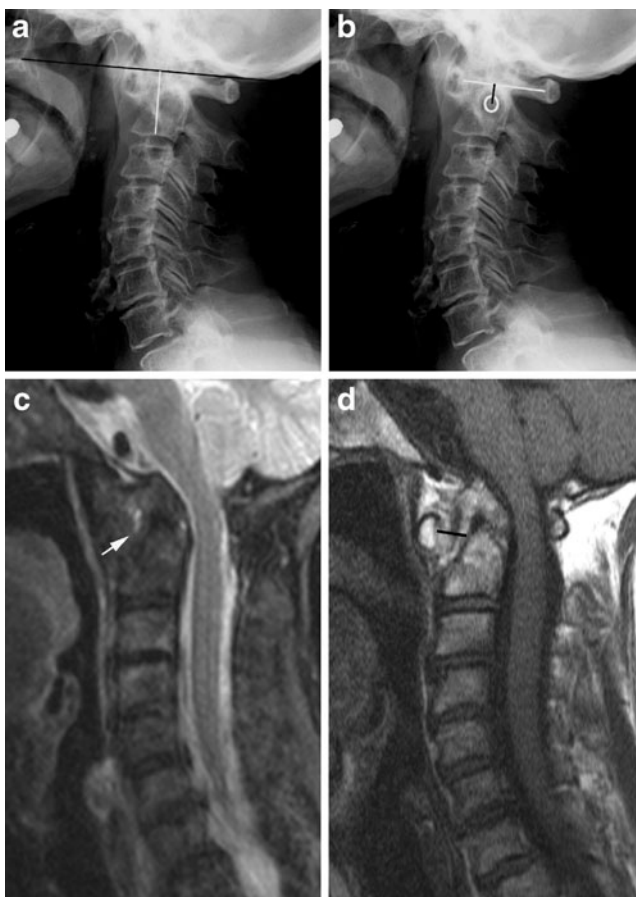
Vertical atlanto-axial subluxation, measurement methods. (a) Lateral normal radiograph in neutral position showing the location of McGregor's line (black) between the postero-superior aspect of the hard palate and the most caudal point of the occipital curve. Migration of the tip of the dens >4.5 mm above McGregor's line indicates vertical subluxation. The distance indicated by the white line between McGregor's line and the midpoint of the inferior margin of the body of axis is used to evaluate vertical subluxation according to Redlund-Johnell and Pettersson's method. A distance less than 34 mm in men and 29 mm in women indicates vertical subluxation. (b) Sagittal CT
